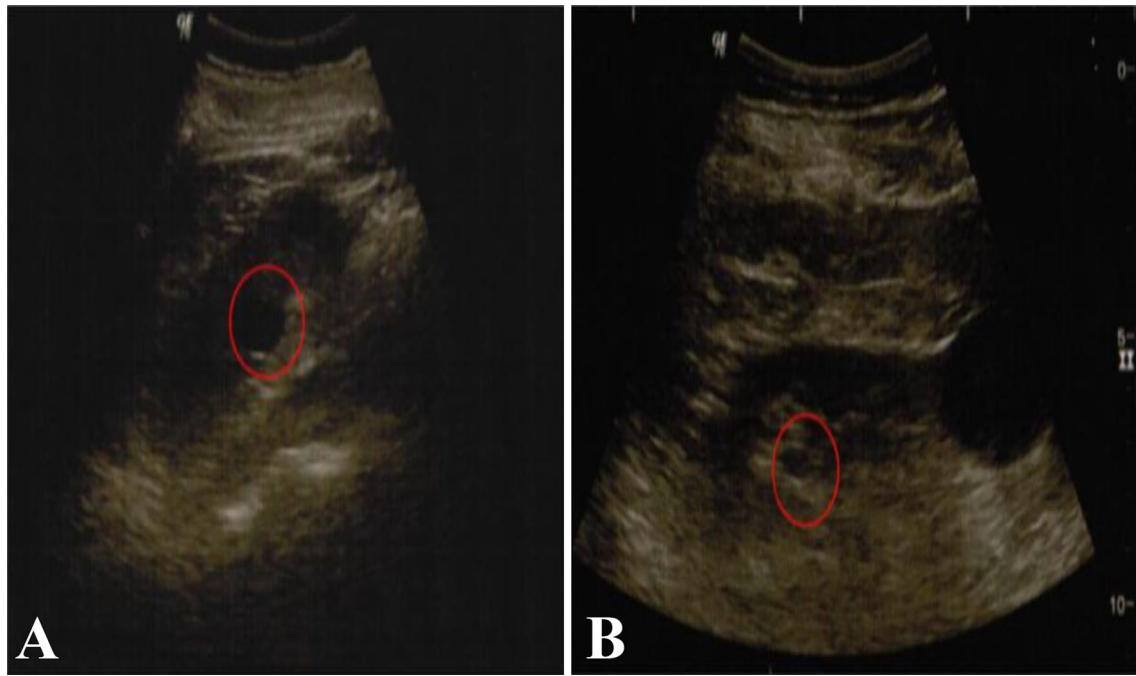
Evaluation of parapelvic cysts with ultrasound imaging
